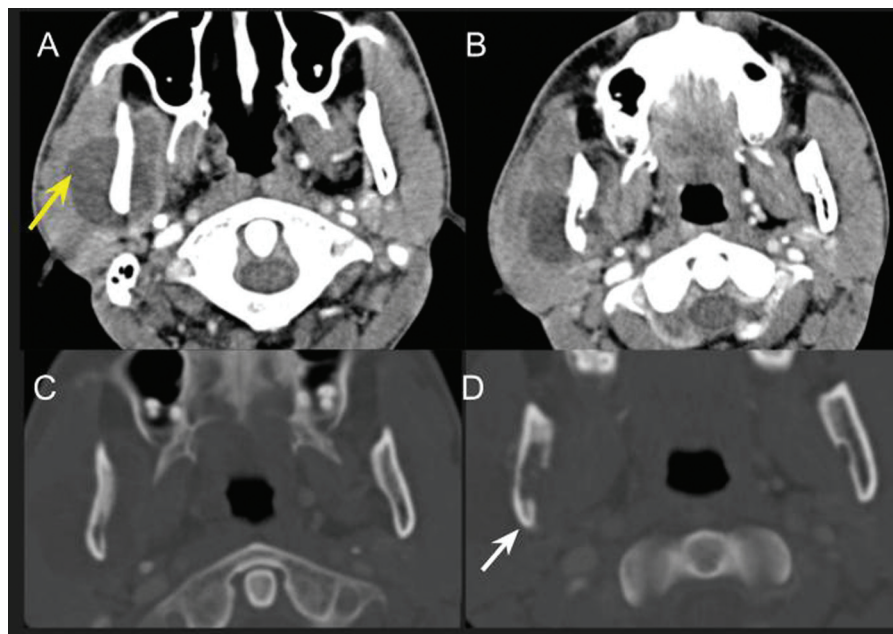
Tuberculosis of the jaw. Soft tissue (A, B) and bone window computed tomography (CT) images (C, D) of a 22-year-old female right preauricular swelling shows lytic lesion with cortical destruction of the right mandibular ramus (white arrow) associated with soft tissue abscess formation in the adjacent masseter and medial pterygoid muscles with an increase in muscle bulk (yellow arrows).
